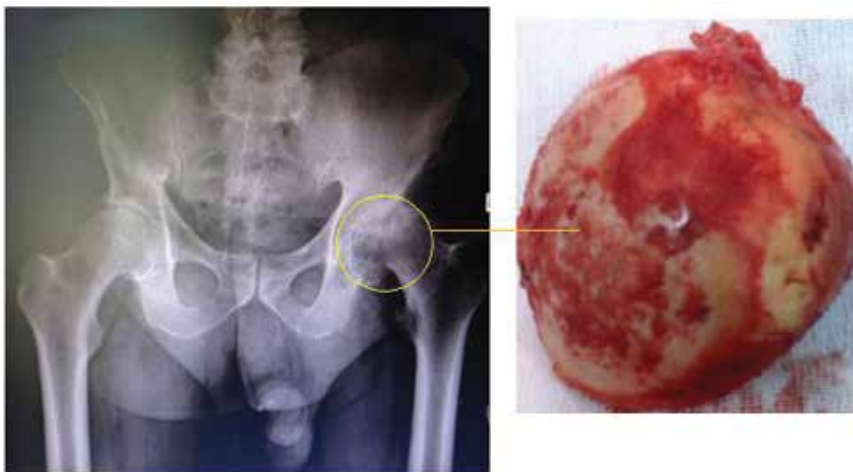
Radiographic image of diseased femoral head and its photography.
